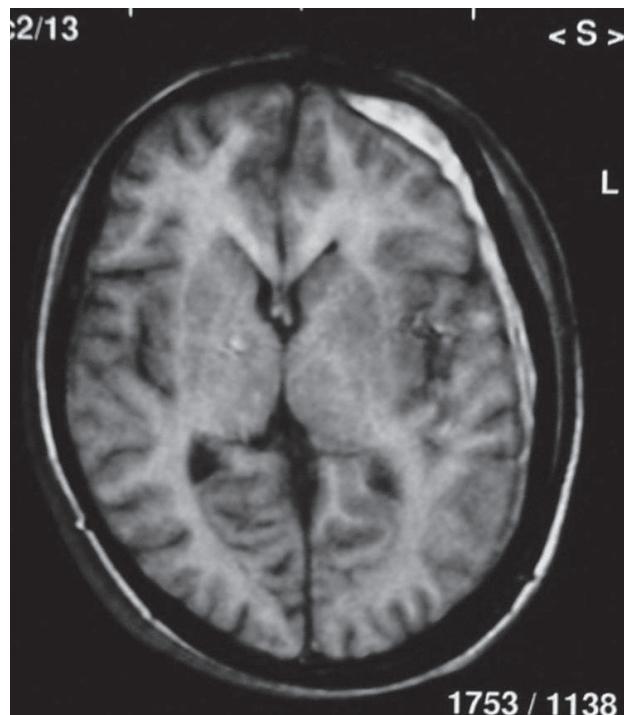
MRI T1-weighted image in the axial plane.
